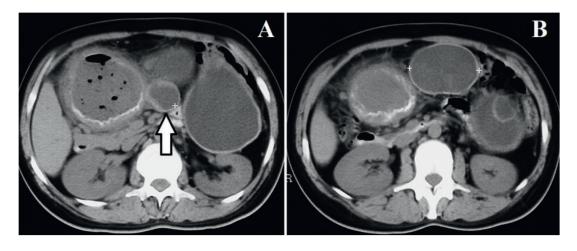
(A, B) axial computed tomography scans of a patient with abdominal cystic echinococcosis with multiple locations including body of the pancreas (arrow, a).
